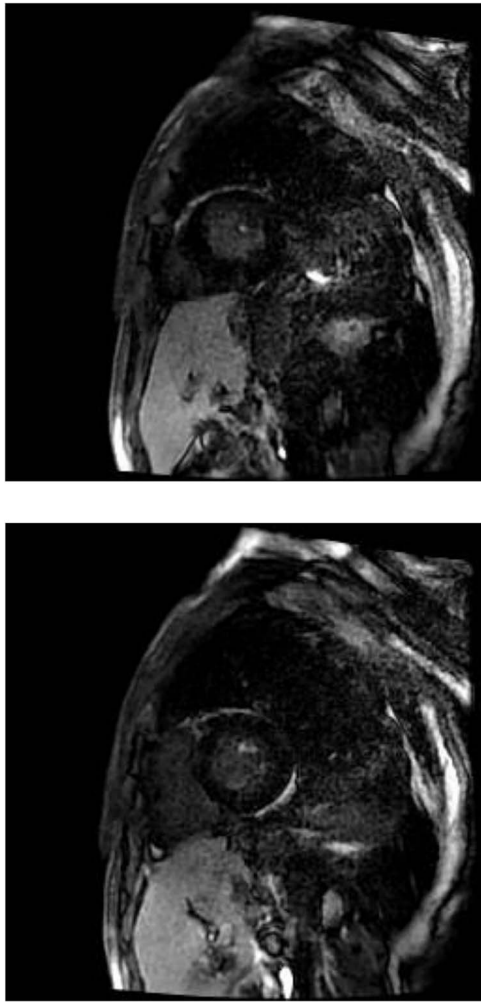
Short axis images from patient's cardiac MRI showing an area of late gadolinium enhancement of the anterolateral papillary muscle, which likely represents scarring caused by her previous NSTEMI.
